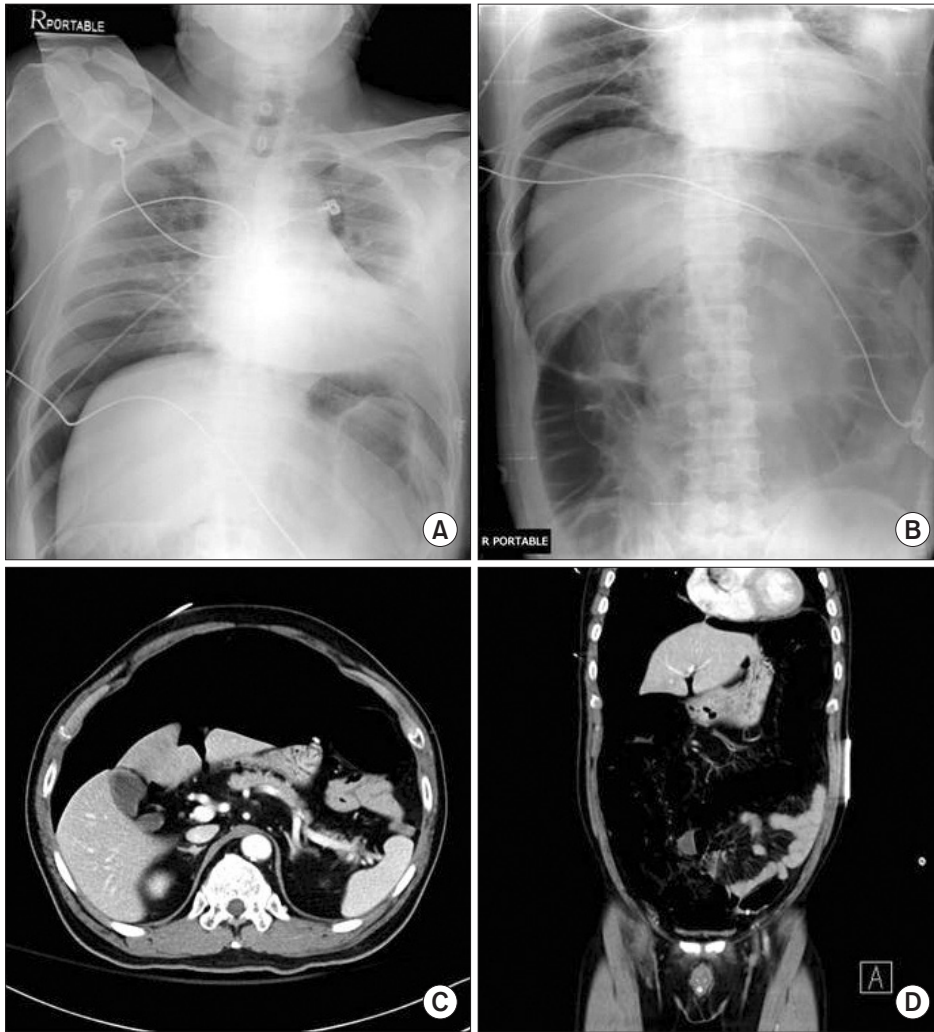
Radiologic findings of tension pneumoperitoneum. (A) Chest PA. (B) Plain abdomen. (C) Abdominopelvic CT, axial view. (D) Abdominopelvic CT, coronal view.
